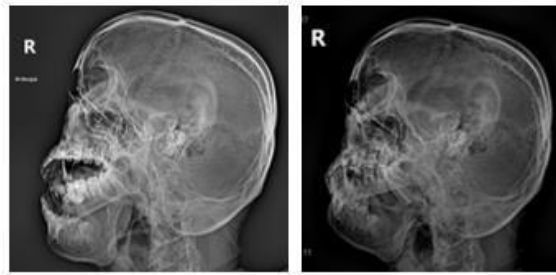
Radiograph of the Temporomandibular Joint, Axialateral Projection, 250 Caudal Angle
